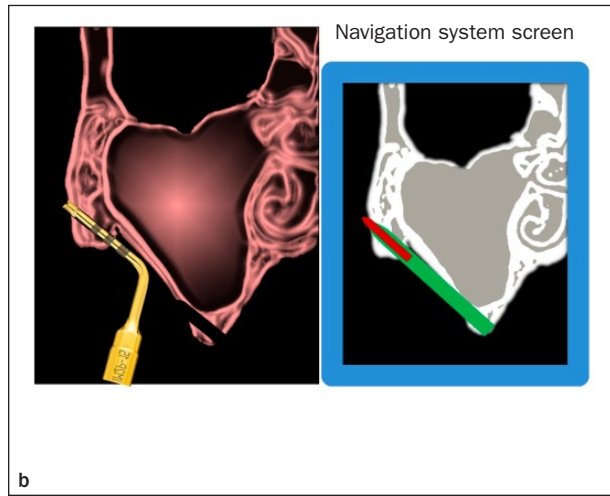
(Below) Two-step zygomatic implant site preparation using an image-guided system and an angled standard-length piezosurgery tip: separate preparation of (a) the crestal bone and (b) the zygomatic bone. The planned implant trajectory (green) can also be followed on the navigation system screen with the ultrasonic tip position and axis.
